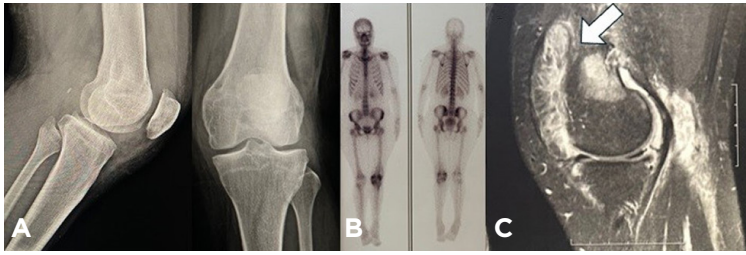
Initial image investigation. A) X-rays without gross abnormalities; B) Bone scintigraphy revealing isolated left knee compromise; C) Initial MRI scan. Arrow points to synovial thickening that was misdiagnosed as an arborescent lipoma.
